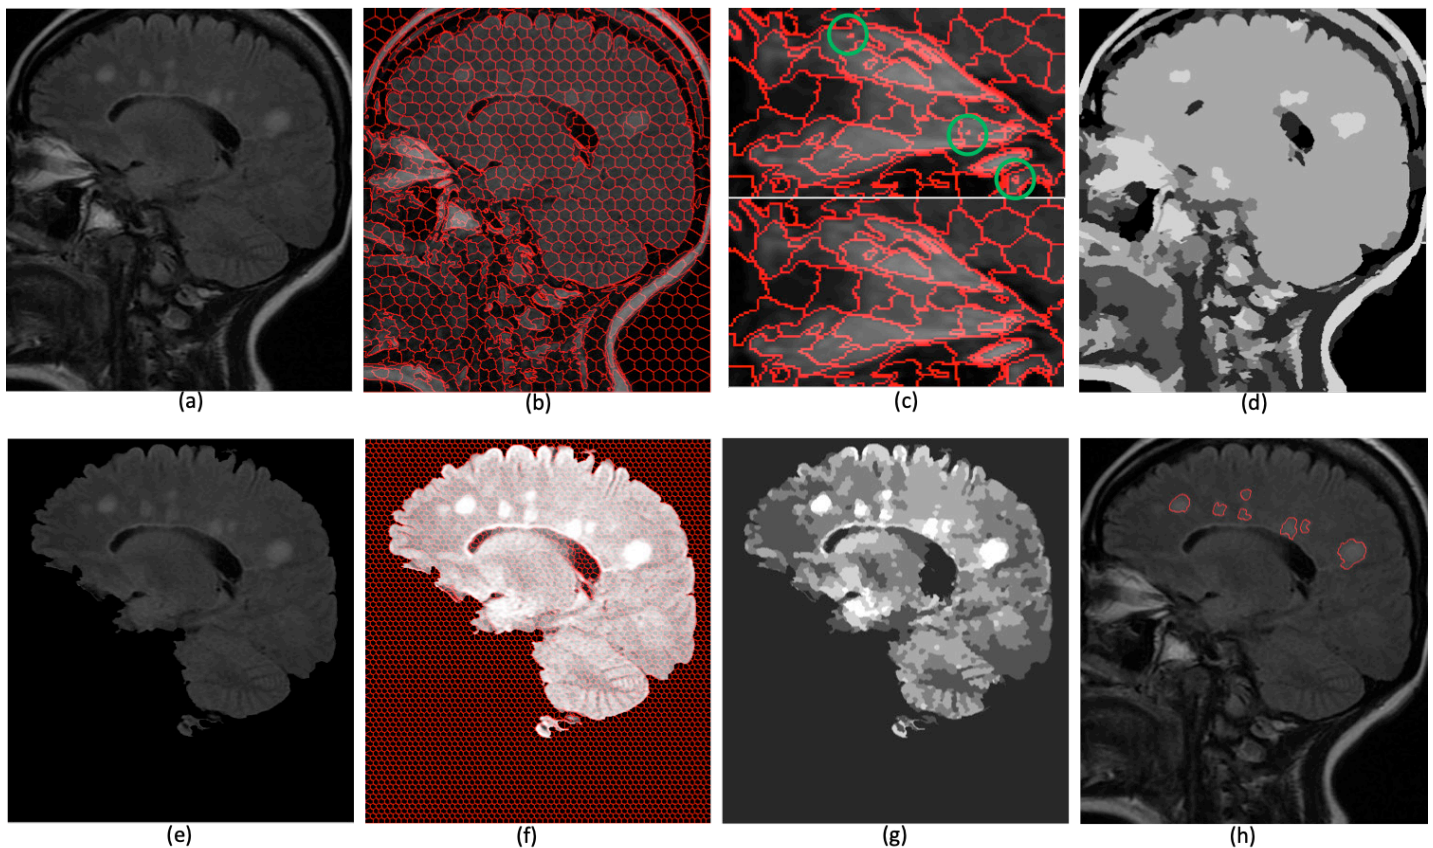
Complete process for detection of lesions in the brain. (a) Sagittal MRI input image of 520x459 pixels, (b) image segmented in superpixels with $\gamma = 0.1$ and 1000 desired clusters (resulting in $K = 972$ clusters), (c) Zoomed region where small clusters are shown circled in green (top), result of the fusion process where small regions were merged (bottom), (d) Result of GMMF segmentation with 10 iterations, $\lambda = 0.1$ and $k = 0.1$, (e) Isolated brain area, (f) Segmentation of the intensity-adjusted brain region in 5000 super-pixels, resulting in $K = 5453$ clusters after connected component were found, (g) GMMF segmentation of the brain region, (h) final result detecting 7 lesions in the white matter with eccentricity less than 0.9 and area of at least 80.
